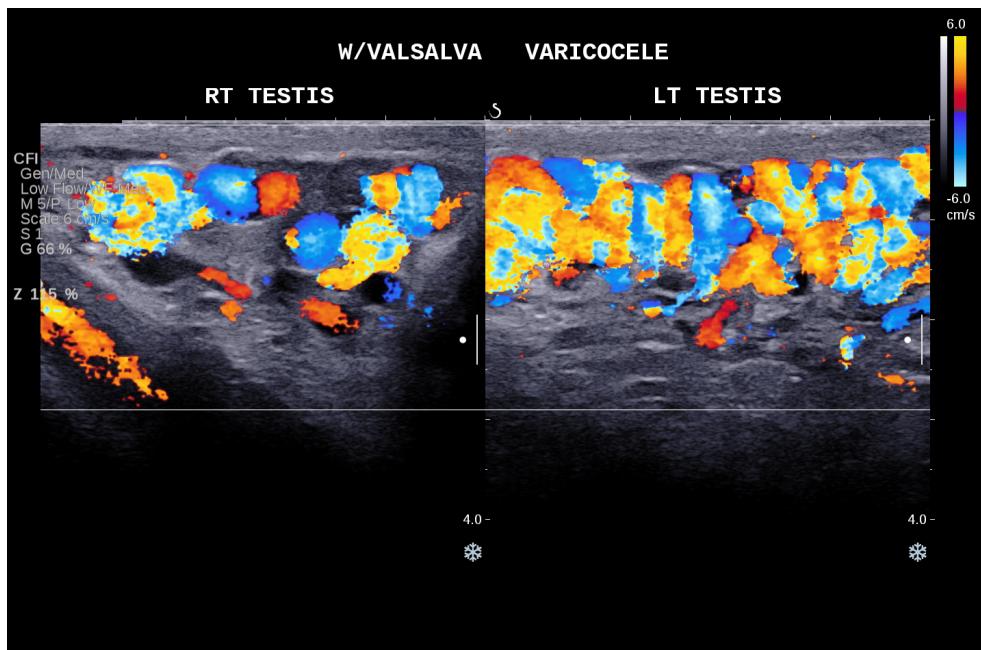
Varicocele. Pictured here on scrotal ultrasound is a varicocele identified by the presence of multiple low reflective tubular structures with internal doppler flow.
